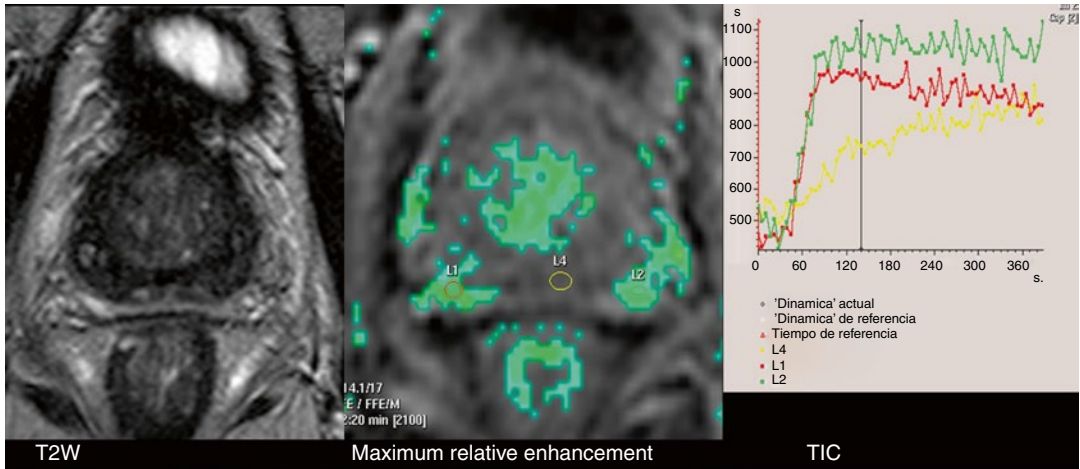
Prostate carcinoma treated with external radiotherapy 9 months ago. Follow-up MRI demonstrates diffuse low signal intensity on T2-weighted image on peripheral zone that prevents tumor detection. Maximum relative enhancement parametric map of DCE-MRI shows two foci of increased enhancement bilaterally on the peripheral zone which show type III TIC (red ROI L1
